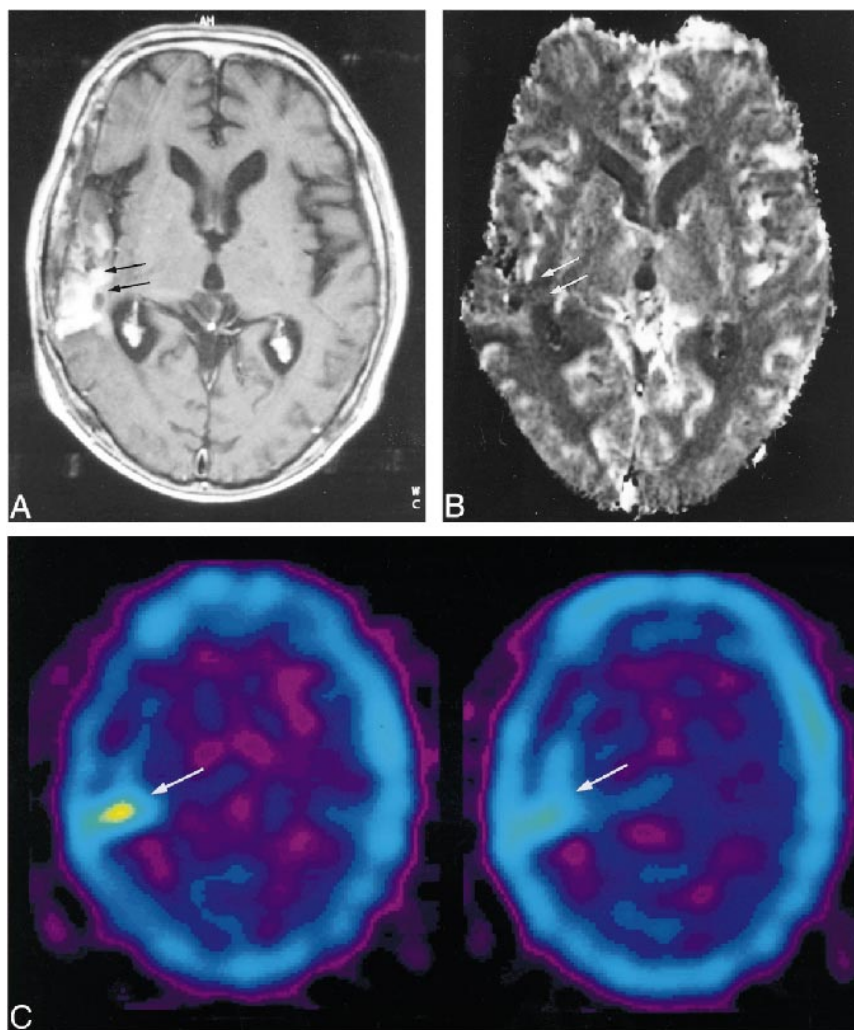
78-year-old man with a recurrent glioblastoma. The diagnosis was determined by the progressively enlarging area of enhancement on serial MR images and by the patient's clinical deterioration.
